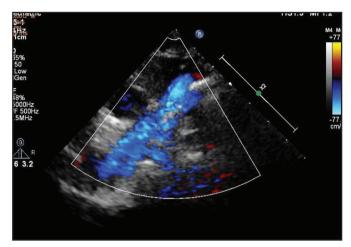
TTE with the suprasternal image showing colour Doppler flow mapping confirming flow from the left superior vena cava to the left atrium.
